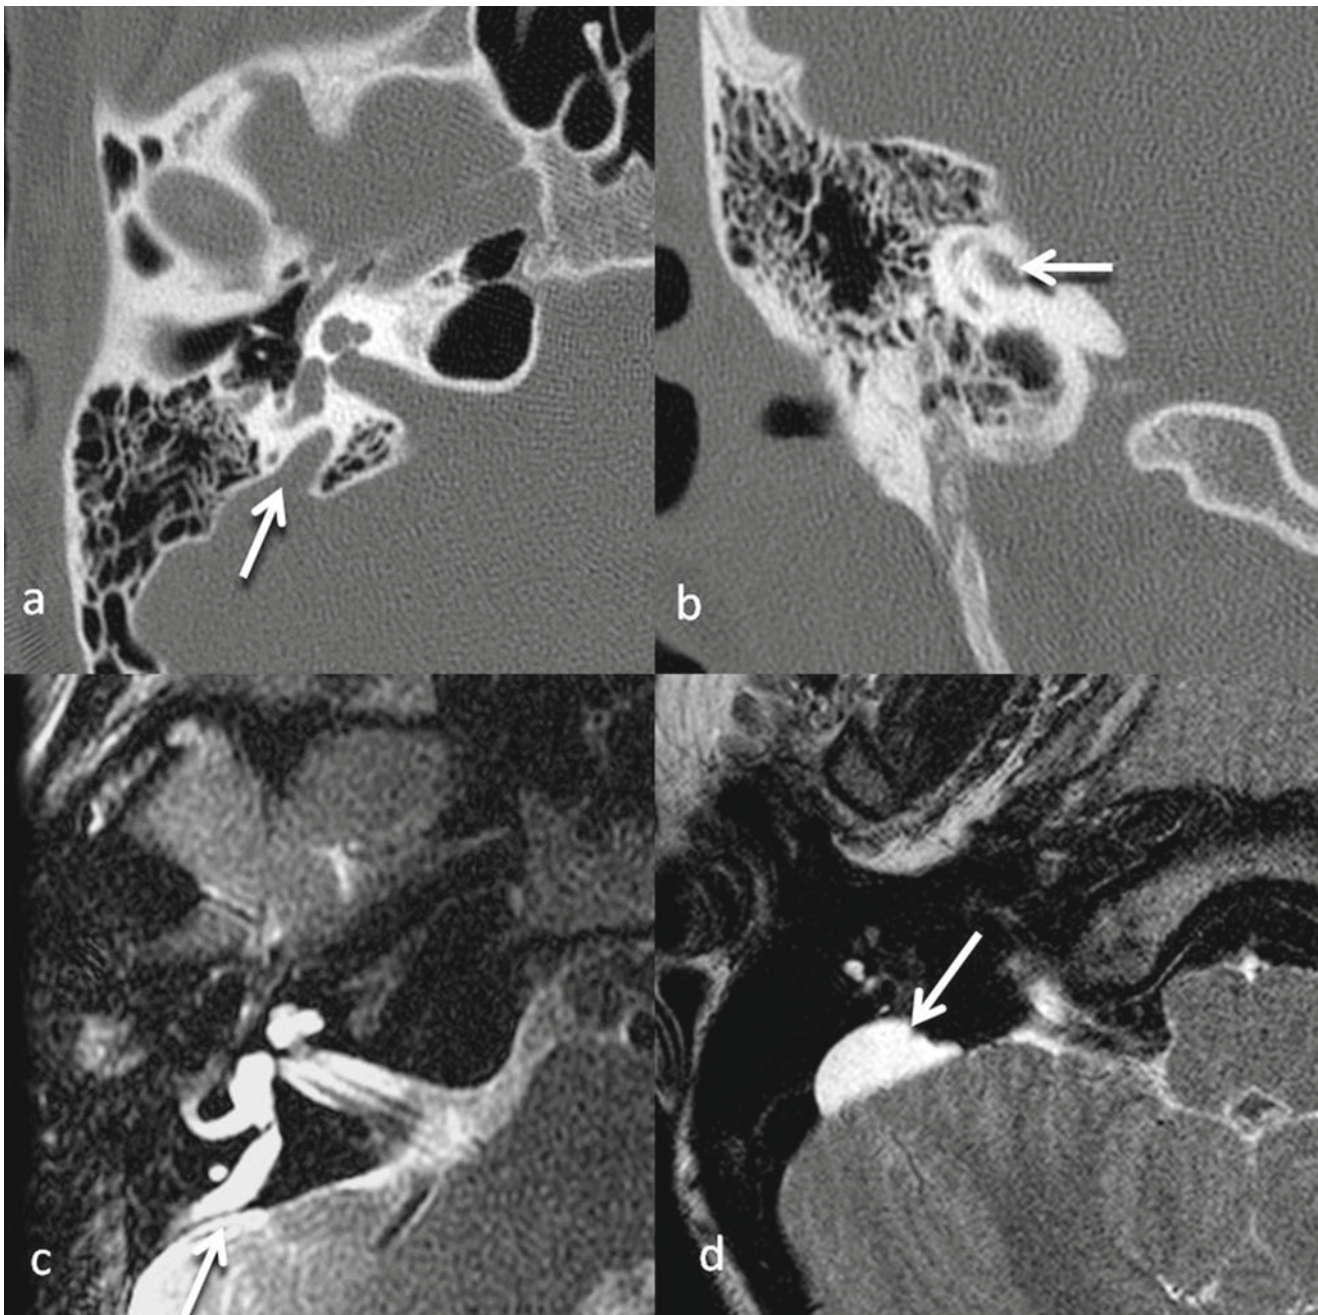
Incomplete partition type 2 (IP-2) (Mondini) malformation. CT right ear (a) axial and (b) coronal images reveal enlarged bony vestibular aqueduct (*arrow*). Additionally, the modiulus is not well formed.
